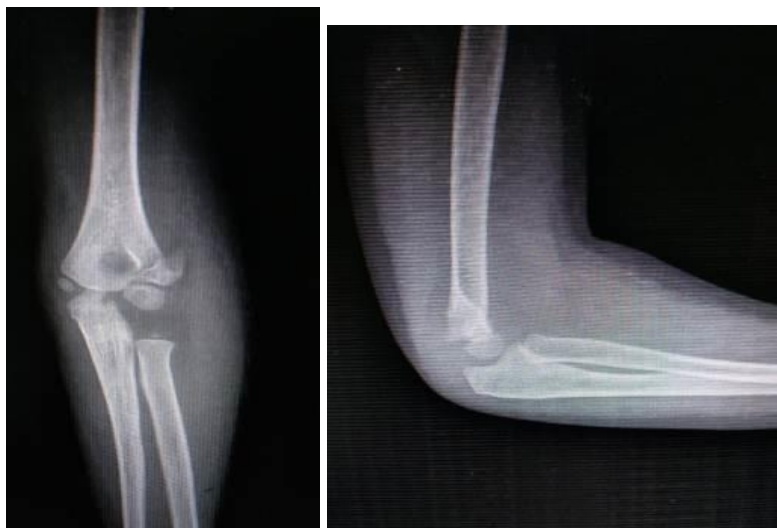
Preoperative x-rays of case no.2
